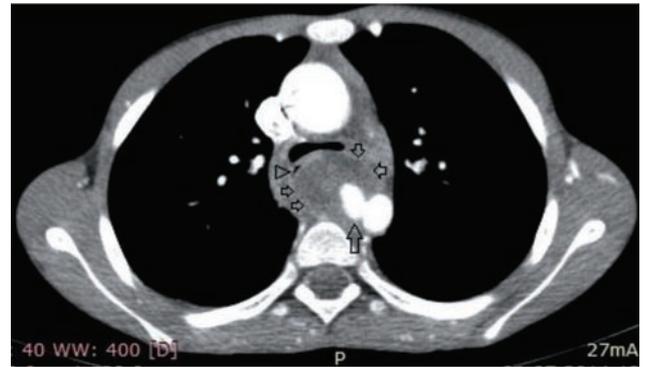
An axial contrast-enhanced CT angiography image demonstrates a saccular aneurysm (long arrow) which is surrounded by a large haematoma (short arrows). Haematoma caused marked compression, and right deviation of esophagus. Marked narrowing of the lumen of esophagus is seen (arrowhead). Also a mild compression to trachea is shown. Intercostal-paraspinal collaterals and dilated internal thoracic arteries are seen.
